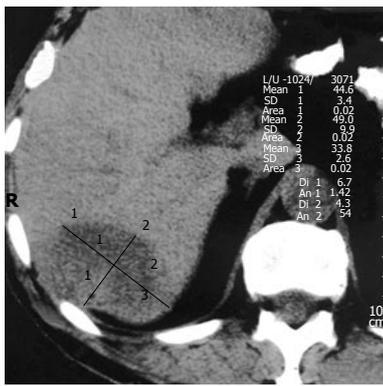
Abdominal CT showing presence of the right lobe tumor of the liver.
